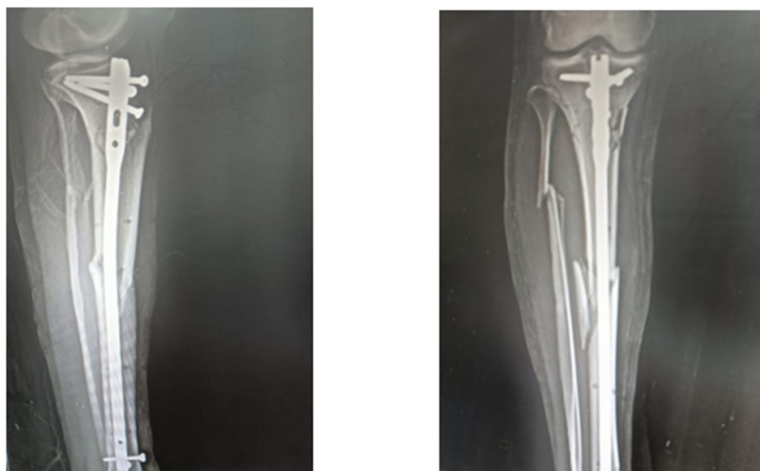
Post operative x-rays (Lateral and AP views).
